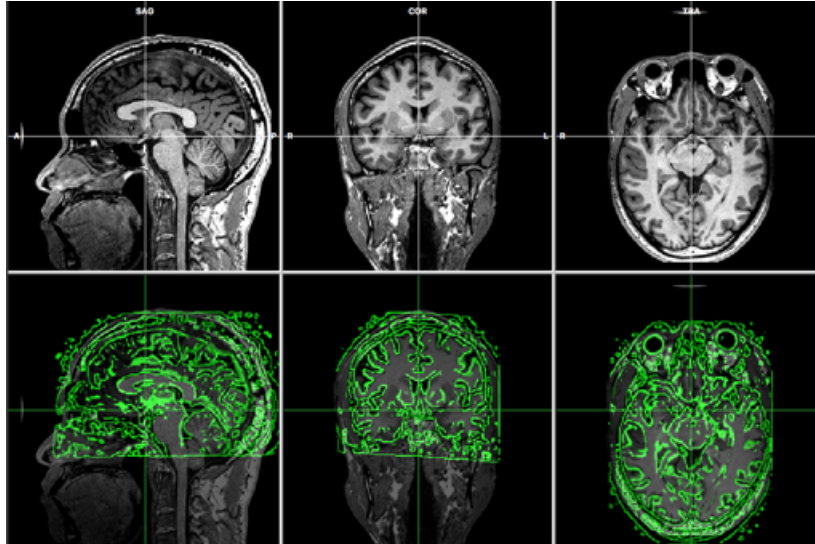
Results of the co-registration between the anatomical MRI and the DTI of the same subject.
